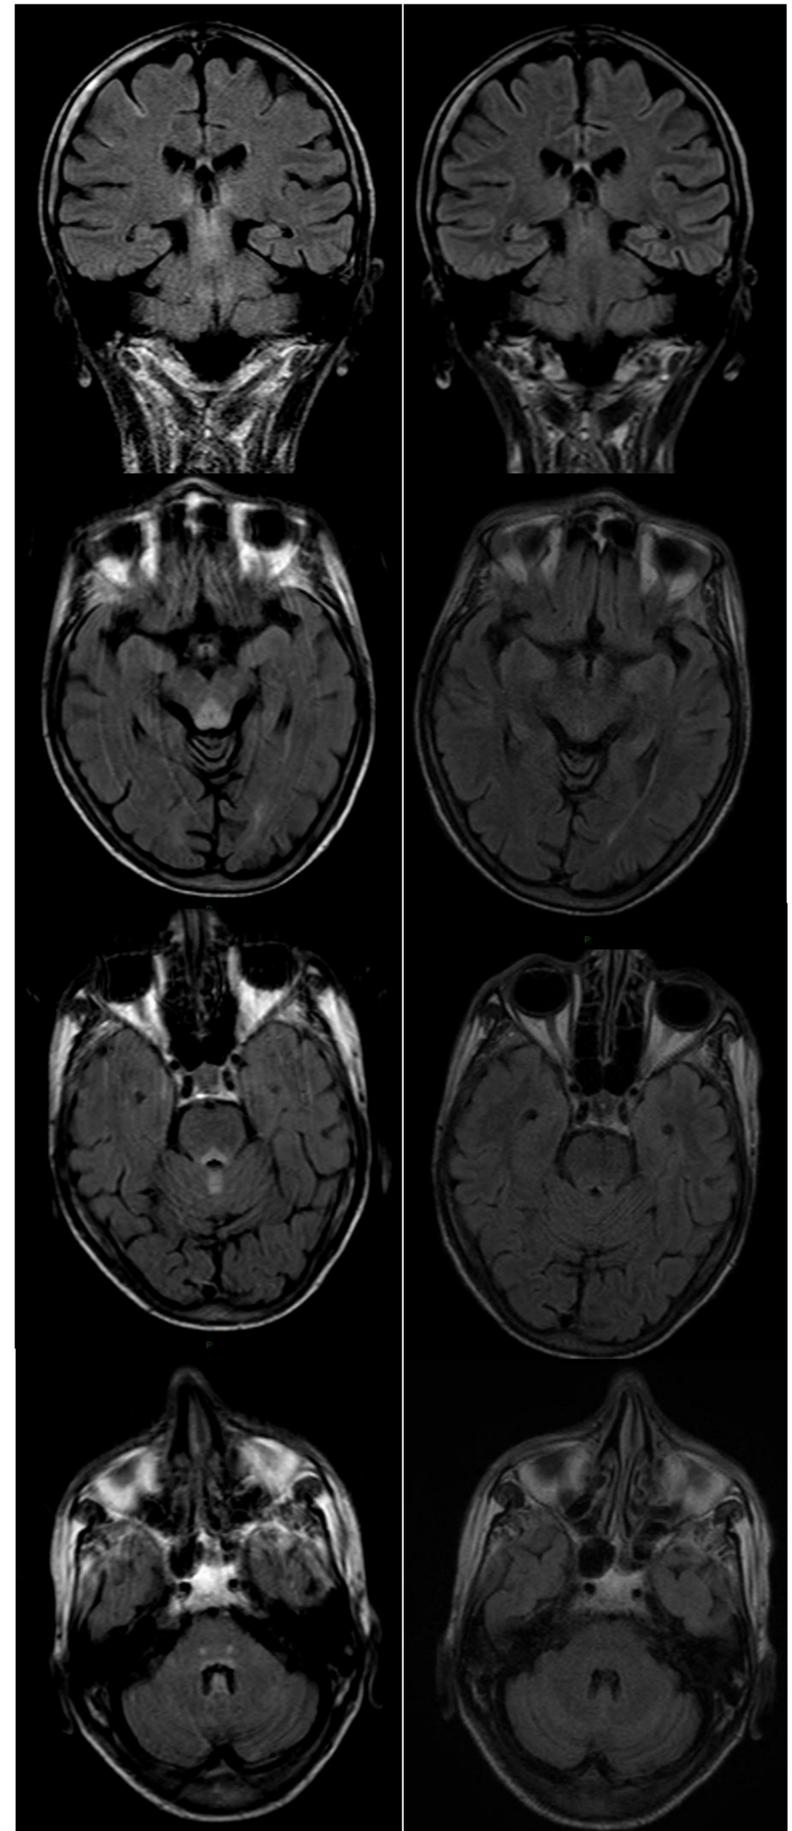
Brain T2-FLAIR MR scan at admission showed a symmetrical bilateral hyperintensity area surrounding the Sylvian Aqueduct and extending also to the thalami and the mammillary bodies. Pathological areas were also visible around the floor of the fourth ventricle, involving the cerebellar vermis, the pons and the medulla (left). MR scan performed seven days after starting intravenous thiamine administration demonstrated the disappearance of hyperintensity areas (right).
